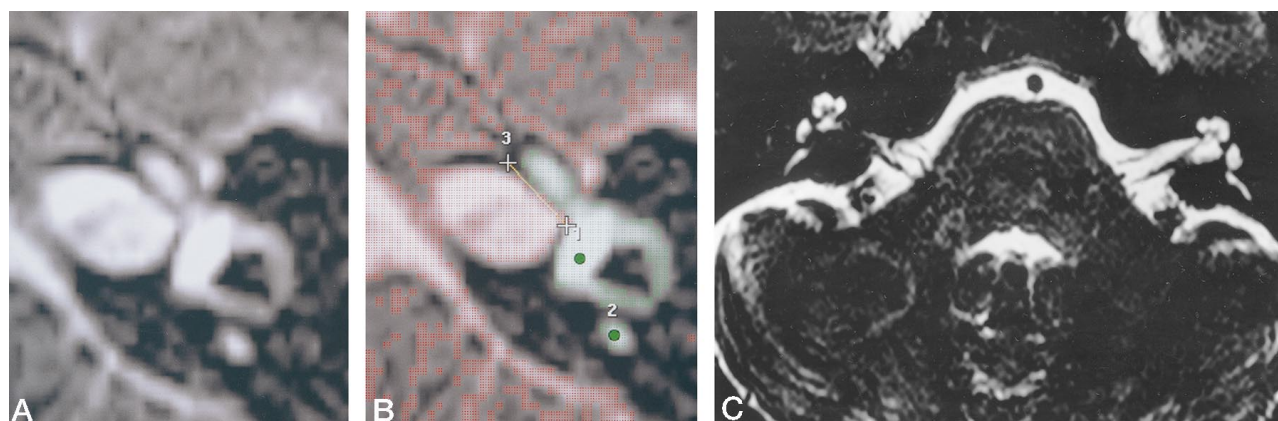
A–C, Axial T2-weighted FSE (2400/200) MR image obtained from the 3D data set at the level of the vestibule (A) and mid cochlea (C). On-line segmentation (B) resulted in highlighting in red all pixels with signal intensities above the set threshold. Pixels highlighted in green were those contiguous with the seed placed in the vestibule by the observers. Structures contiguous with but not part of the inner ear (ie, internal auditory canal) were manually excluded (line 1–3) from the selected volume of interest.
